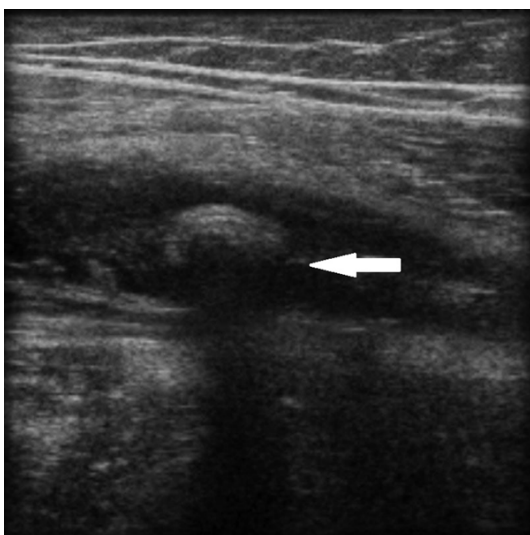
Ultrasound imaging of acute appendicitis (white arrow shows inflamed appendix).
